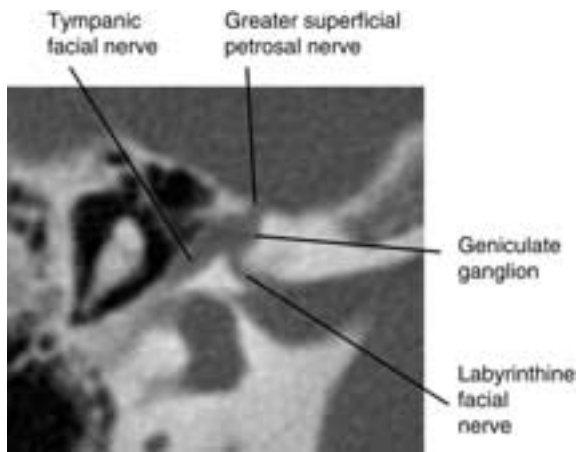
This axial CT section through the geniculate ganglion demonstrates the facial hiatus for the greater superficial petrosal nerve. The thin, bony margin between the lateral margin of the horizontal facial nerve and the middle ear is seen.
